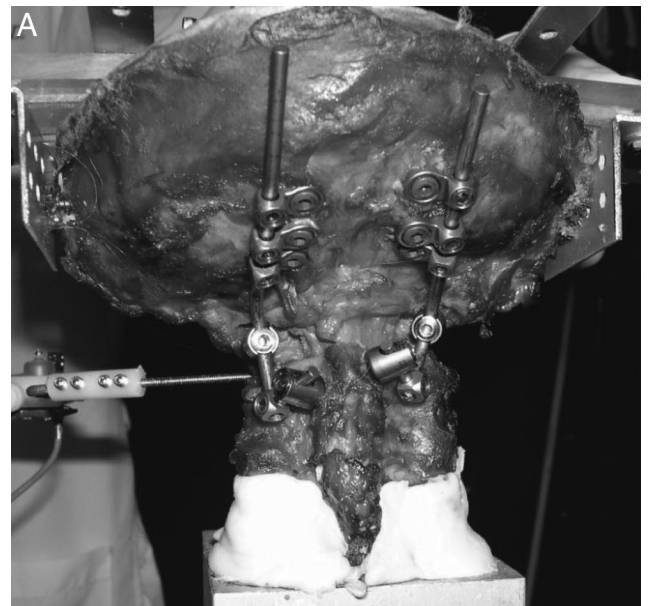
Laminar screw technique using C2 crossing laminar screws. A, Photograph, (B) x-ray.
